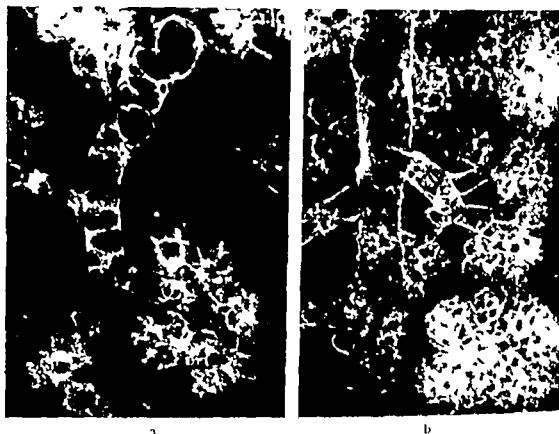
Roentgenmicrograms of normal perinatal lungs: a) Premature infant (BW 1790 g) $\times 2$; b) Full-term infant (BW 3890 g) $\times 10$.
